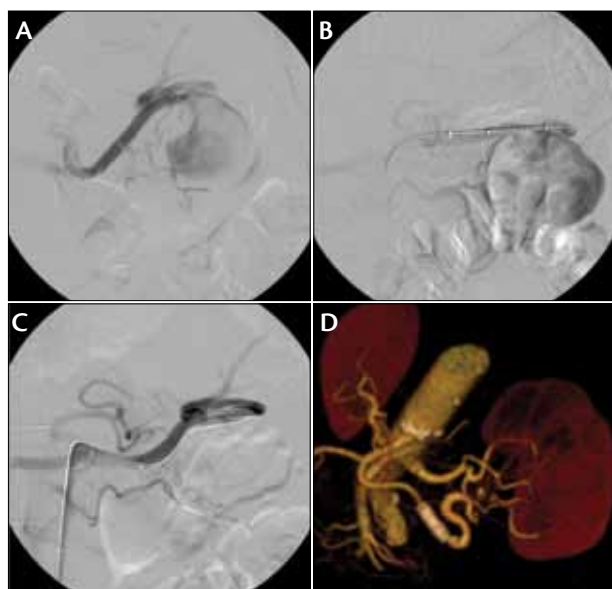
A 58-year-old man with a large SAA. Selective angiography of the SA showing the aneurysmal sac (A). Angiography through the sheath postpositioning of the stent graft and before deployment (B). Stent graft implantation to exclude the aneurysm (C). Computed tomographic angiography with volume-rendering technique at 3 months posttreatment (D).
